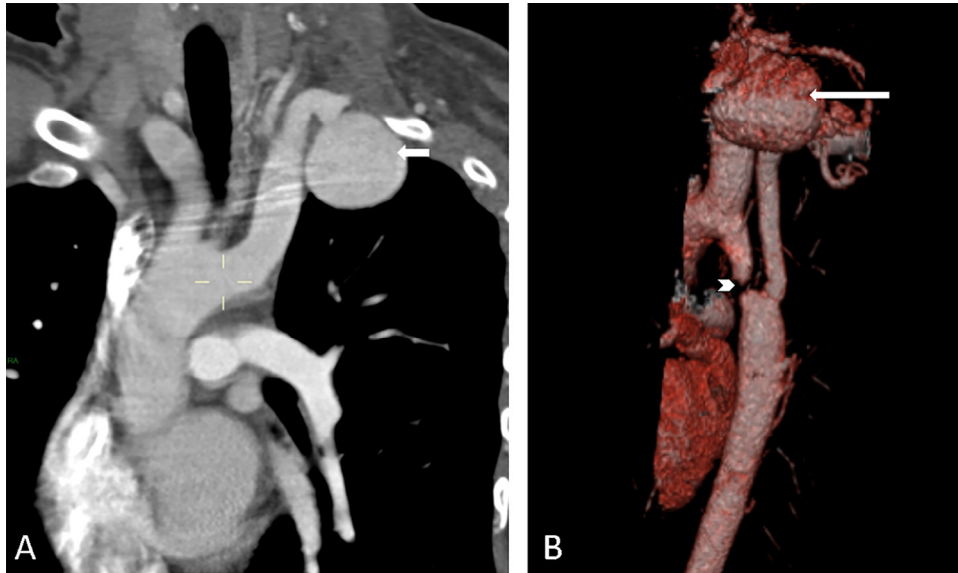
(A) Initial computed tomography with contrast enhancement. Coronal reconstruction shows a left large aneurysm (arrow). (B) Three-dimensional surface reconstruction demonstrates a subocclusive coarctation of the descending thoracic aorta (arrowhead) and the aneurysm (arrow).
